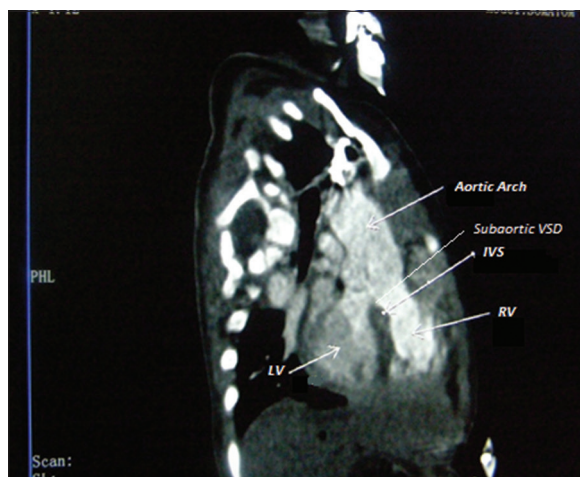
Computed tomography angiography shows tetralogy of Fallot with sub aortic ventricular septal defect. IVS: Interventricular septum, RV: Right ventricle, LV: Left ventricle
